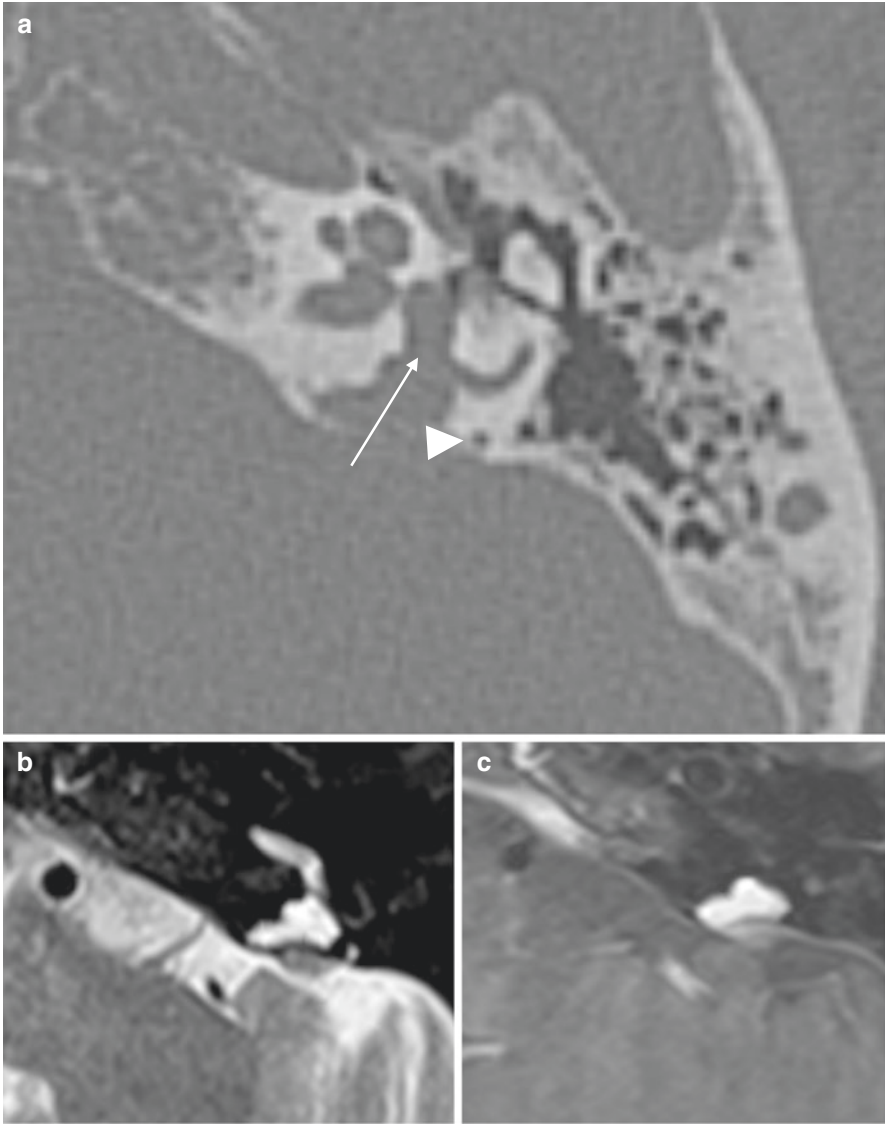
(a) Axial non-contrast CT scan of the temporal bone demonstrates a permeative mass compatible with an endolymphatic sac tumor (arrow). The tumor erodes the adjacent bone, dehiscing the posterior semicircular canal (arrowhead) and vestibule (arrow). (b) Axial T2 weighted MRI demonstrates a hyperintense enhancing mass of same lesion as in (a). (c) T1 post-contrast MRI of the same patient demonstrates an enhancing mass
